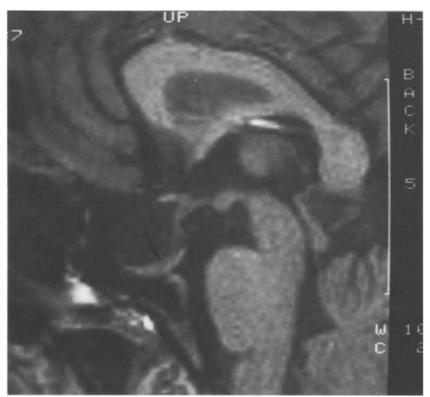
Sagittal magnetic resonance image of enlarged sella. Most of the pituitary fossa is occupied by CSF space not due to enlargement of the infundibular recessus. The pituitary gland is flattened against the sellar floor (arrow). Slice thickness 2 mm (400 ms TR, 24 ms TE)
